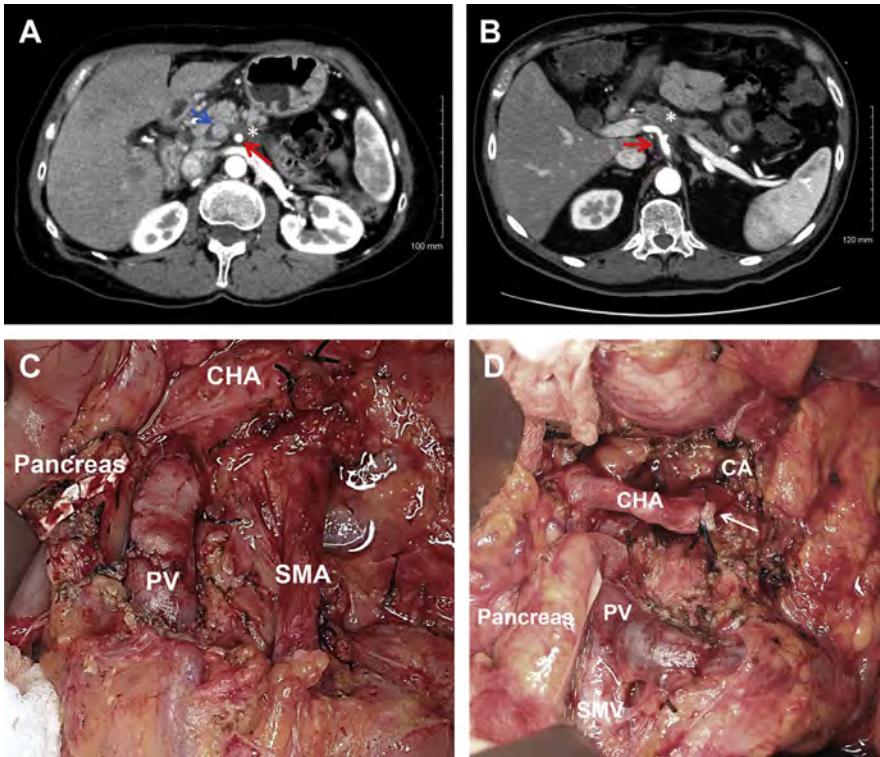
(A) Computed tomography axial image of a locally advanced type A tumor involving greater than 180° of the SMA, (blue arrow) SMV, (red arrow) SMA, (asterisk) tumor. (B) Locally advanced type A tumor involving greater than 180° of the CA. Both tumors were microdissected off the SMA and the CA, respectively, (red arrow) celiac axis, (asterisk) tumor. (C, D) Intraoperative photographs of the respective tumors after being resected; arrow points to the splenic artery stump.
